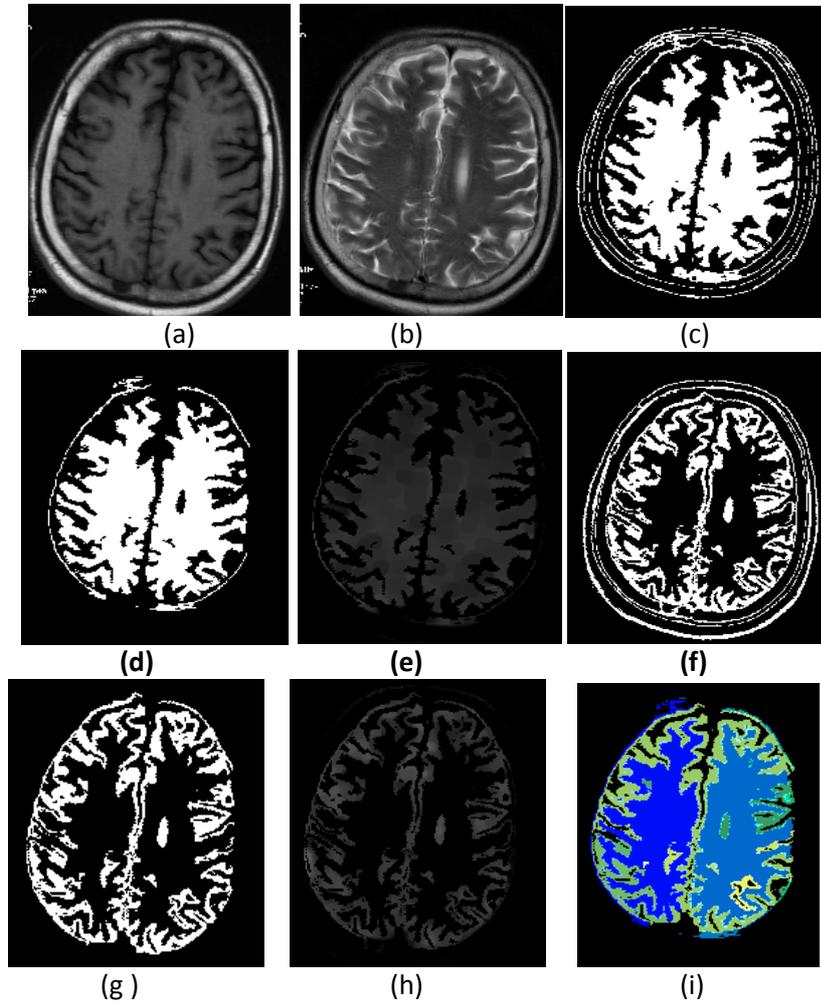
Example for Extraction method applied on a Normal Image. a) T2-Weighted Image b) T1 FLAIR image c) Binary WM with d) Binary segmented WM with outer layers removed e) segmented gray level WM f) segmented binary GM g) Binary GM with outer layers removed h) Gray level GM i) segmented and labeled image
